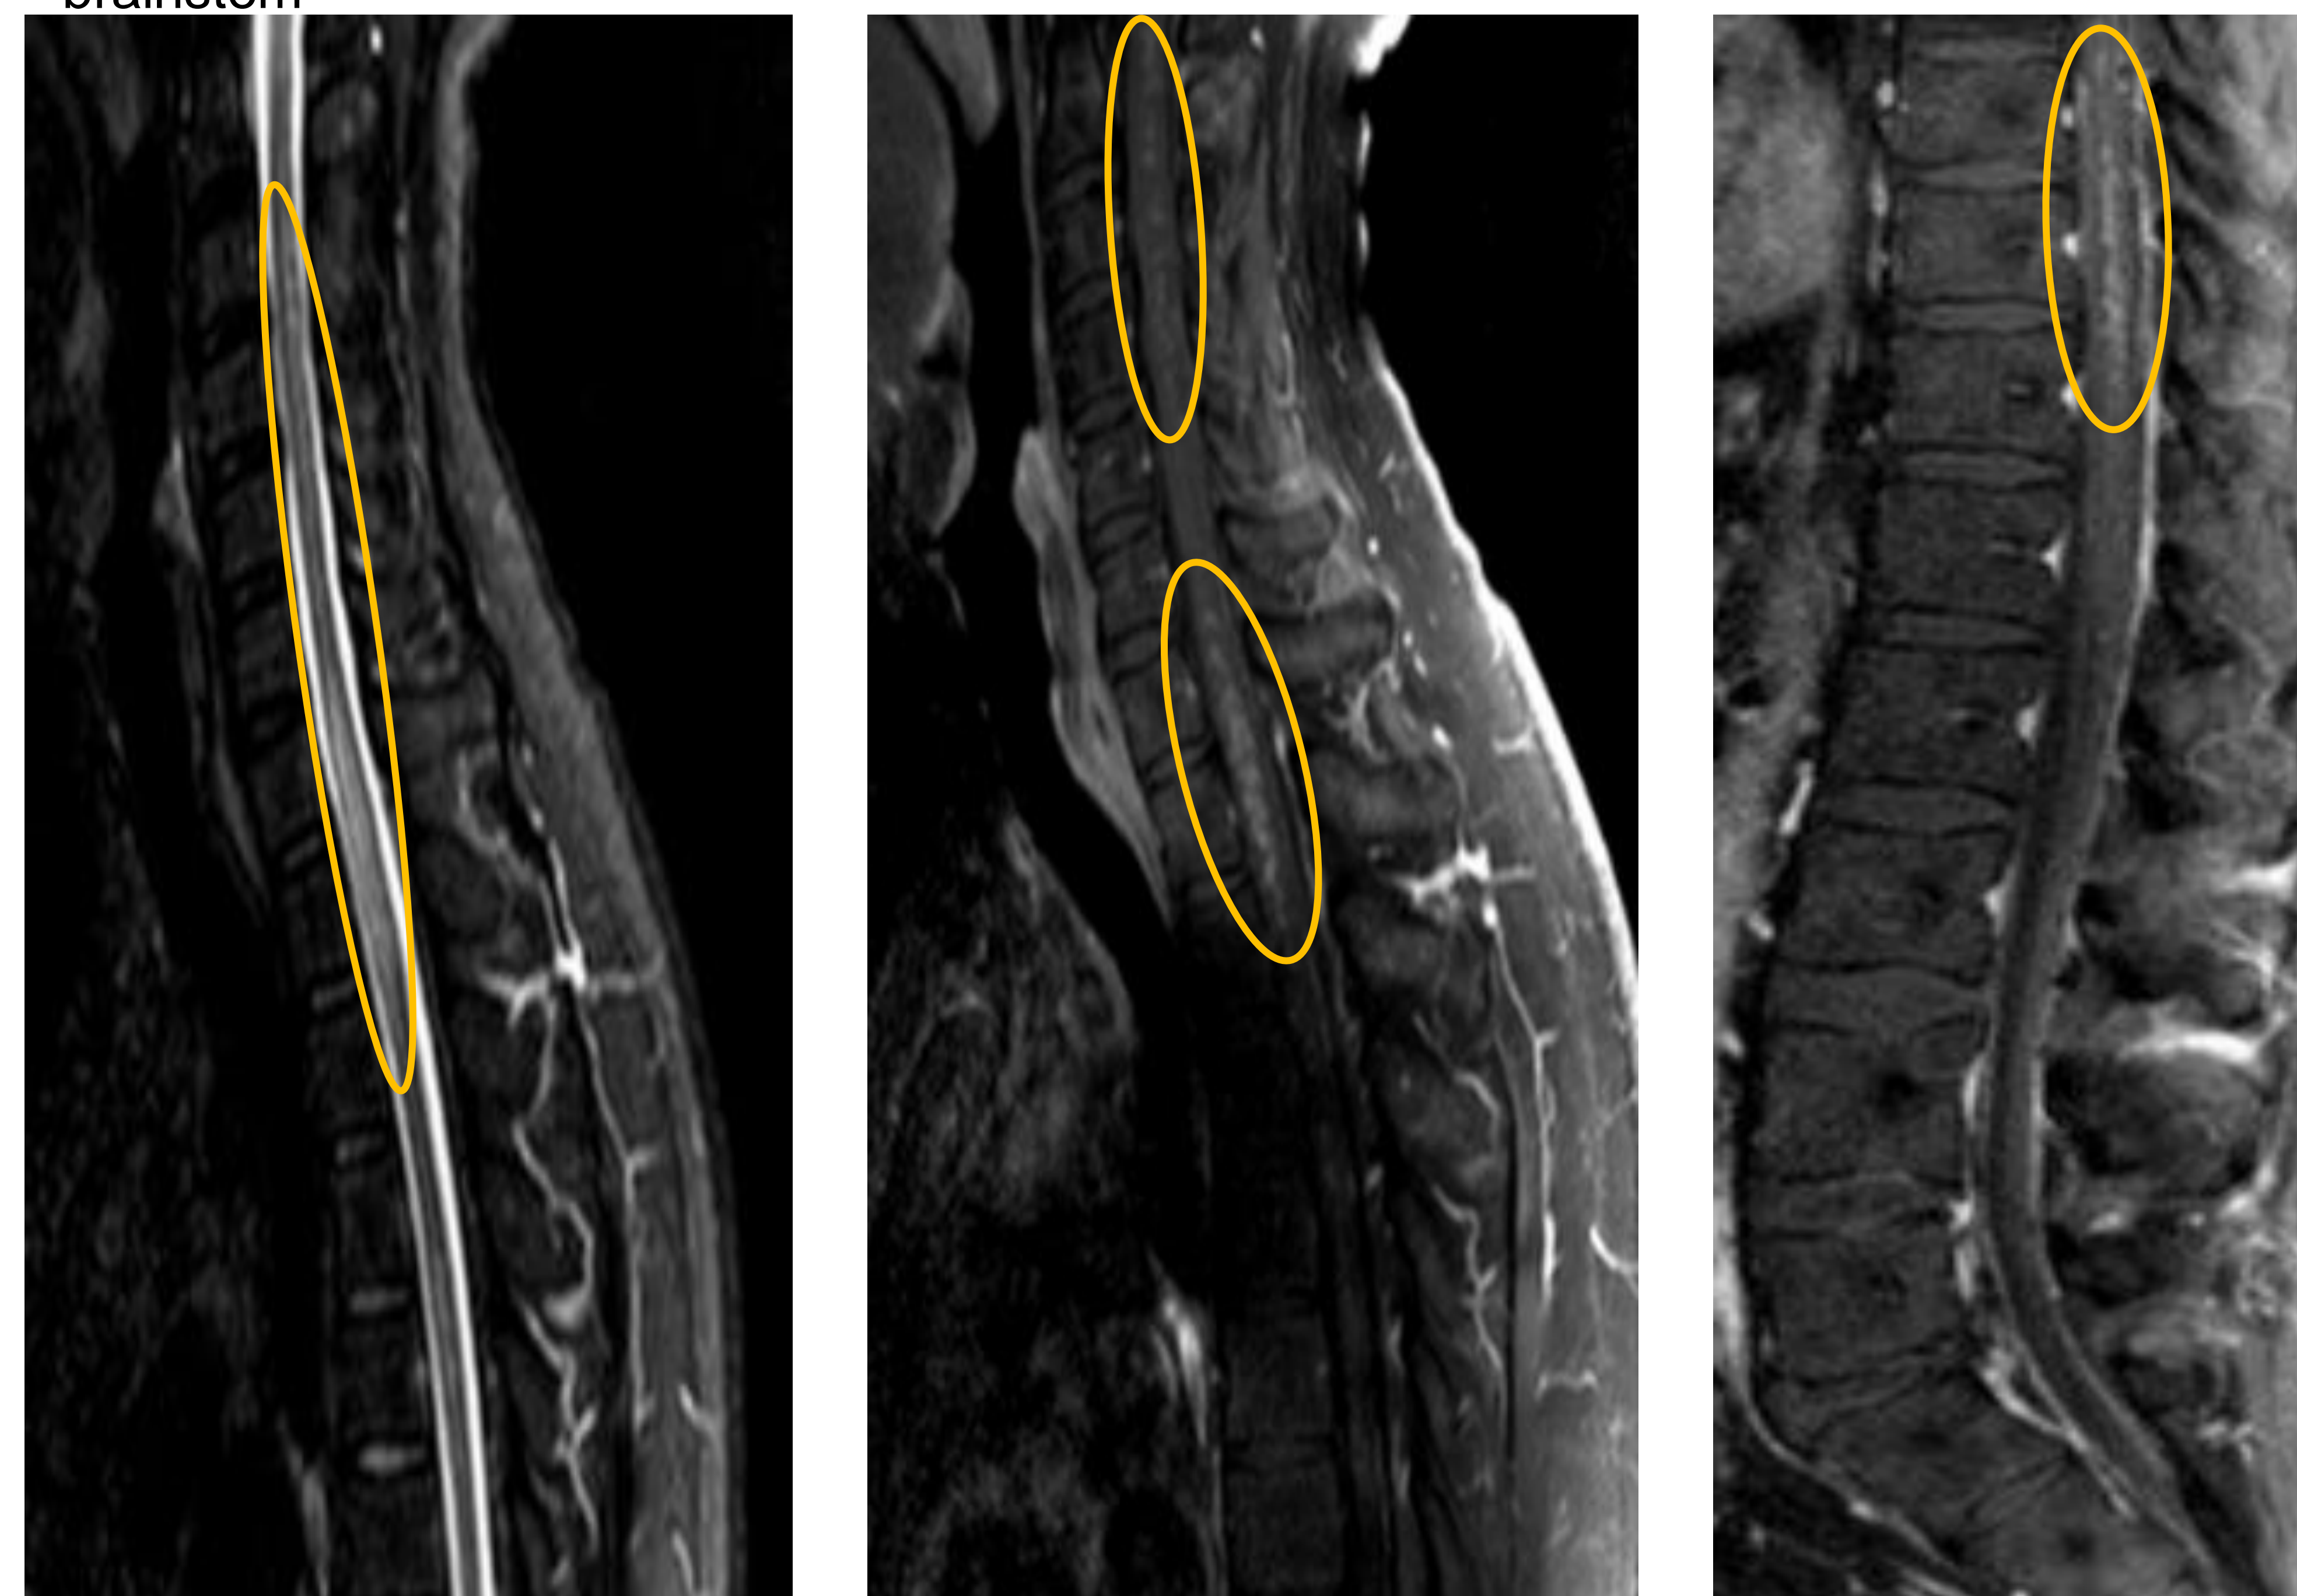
Contrast-enhanced brain MRI demonstrating punctate enhancing lesions throughout the entirety of the spinal cord
